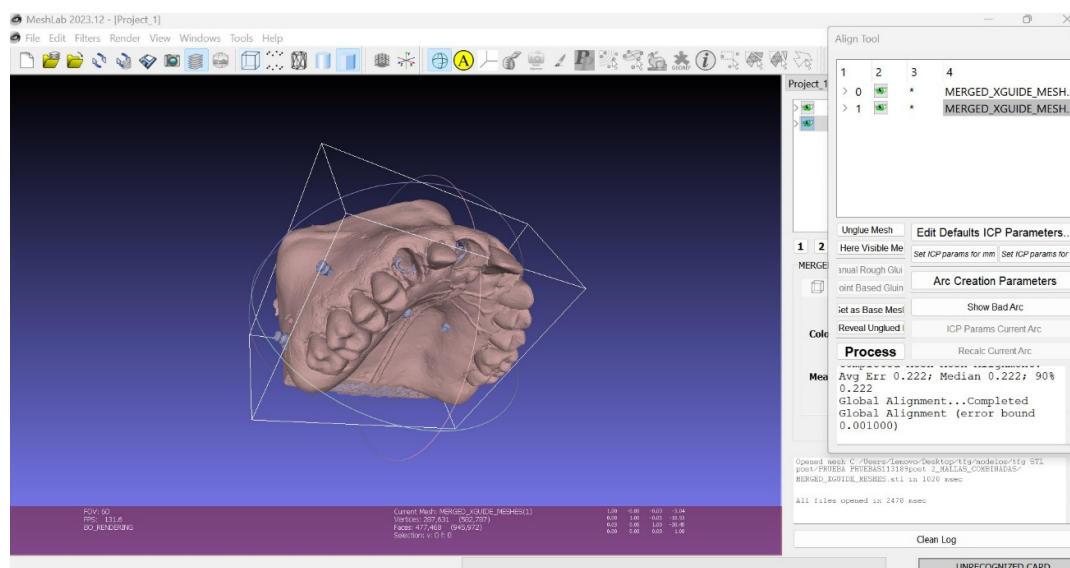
Overlapping of the preoperative CBCT and the final CBCT with MeshLab<sup>®</sup>.
